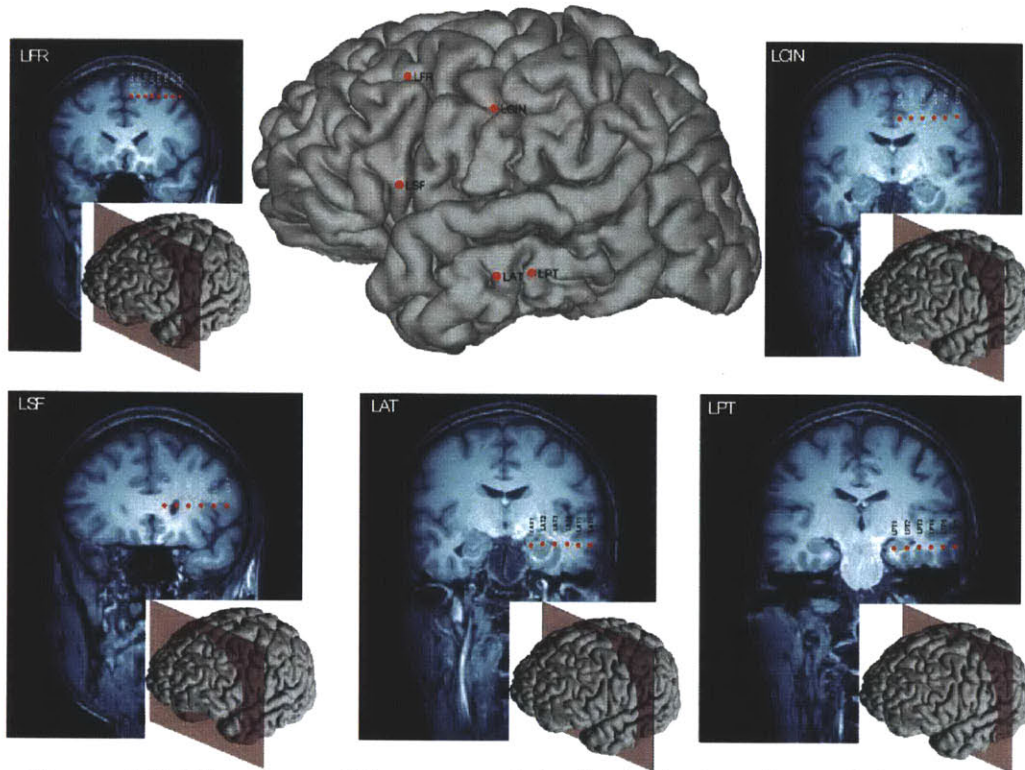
Slice views of five arrays of depth electrodes after reslicing the 3D MRI volume to the long axis of each array. The middle panel shows the entry point for each array overlaid on the reconstructed cortical surface.
